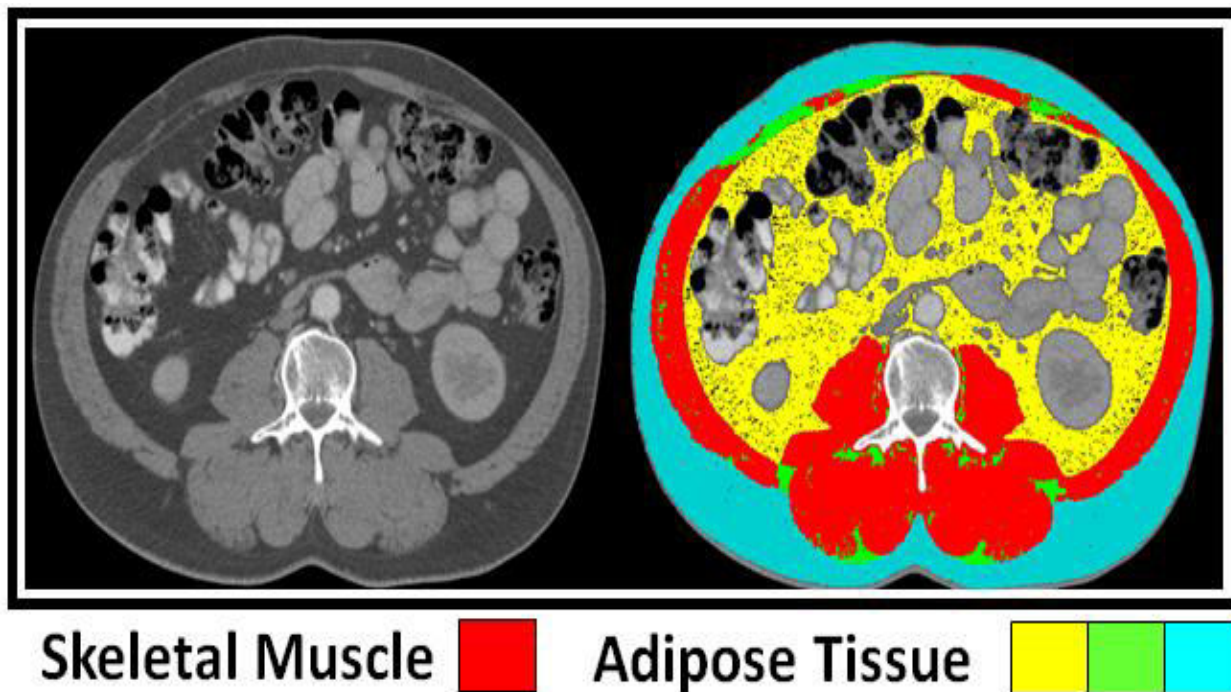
Pre and post CSA analysis of axial CT scans of the 3rd lumbar vertebra for skeletal muscle and adipose tissue depots. Red – muscle CSA (Hounsfield units of -29 to +150), yellow – visceral adipose CSA (Hounsfield units of -150 to -50), green – intramuscular adipose CSA (Hounsfield units of -190 to -30), cyan – subcutaneous adipose CSA (Hounsfield units of -190 to -30).
